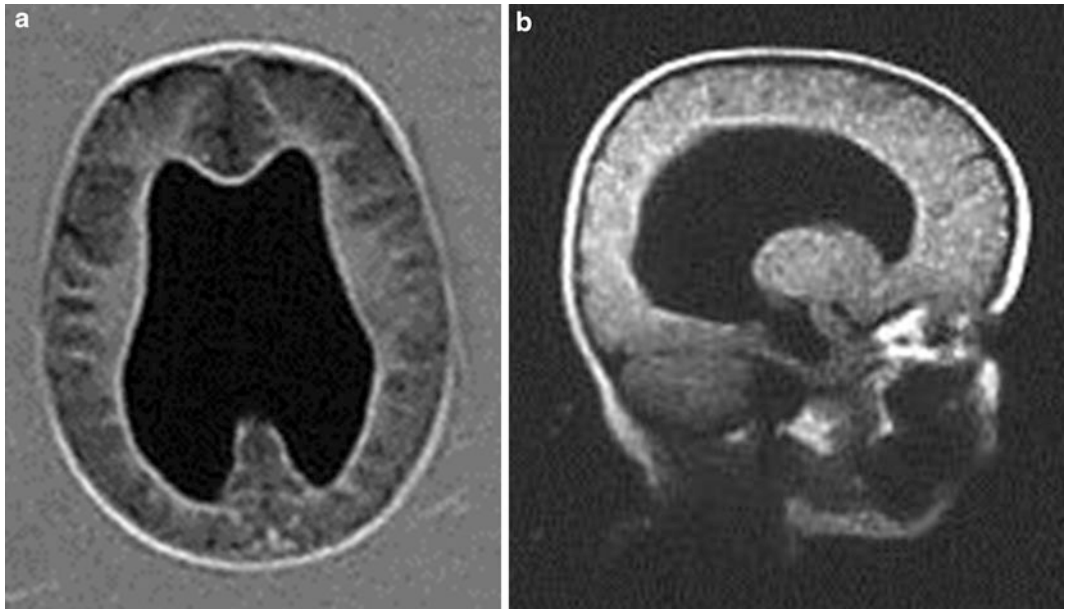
(a, b) MRI of the brain of a patient showing hydrocephalus due to aqueduct stenosis
